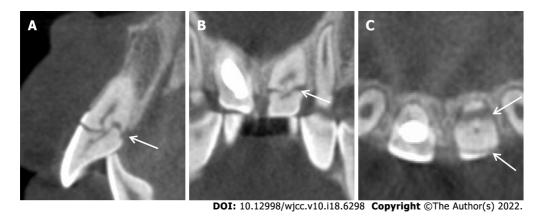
Cone beam computed tomography images showing an oblique crown-root fracture from the labial surface of the tooth 21 with hard tissue deposition at the pulpal side across the fracture line. A: Sagittal; B: Coronal; C: Cross-sectional.
